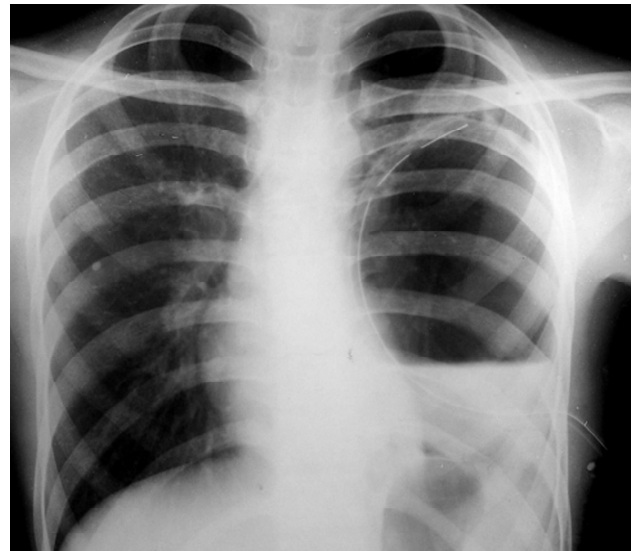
Chest X-ray showed the intercostal tube occupying a cyst in a rounded manner.
